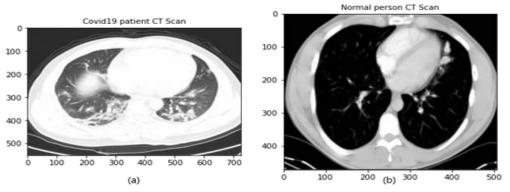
Sample Original images in dataset. (a) COVID CT (b) Normal CT.
